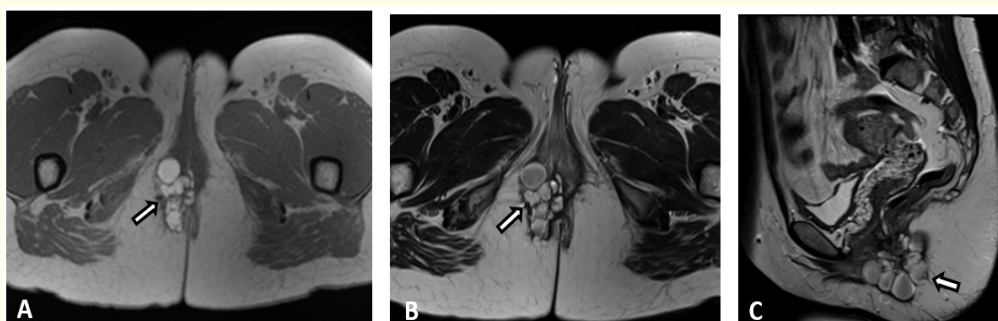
MRI Pelvis: Axial T1 Weighted Image (A), Axial T2 Weighted Image (B) and Sagittal T2 Weighted Image(C) : Show multiloculated cysts, demonstrating T2WI shading and bright T1WI signal intensity, highly concerning of ectopic endometrial glands and endometriotic cysts. Extension of the ectopic endometriotic tissue is noted along the inter-sphincteric space at 10 through 12 o'clock position (arrows). The approximate size of the perineal endometriotic mass is 5.3 cm x 3 cm in AP and transverse dimensions respectively.
